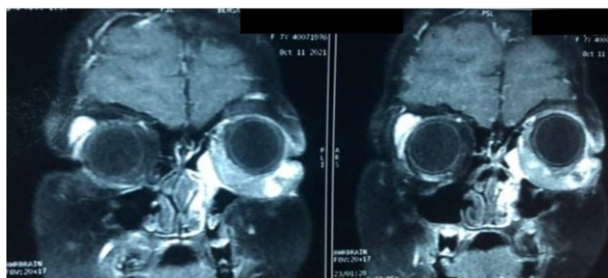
Magnetic resonance imaging showing enhanced mass in the inferior aspect of the left orbit involving orbital soft tissue and extraocular muscles.
